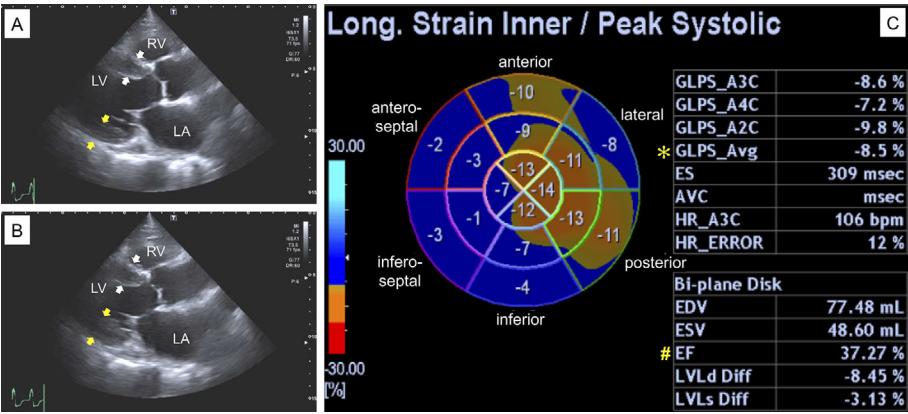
Echocardiogram findings recorded on admission (Case 2). A normal-sized left ventricle with an end-diastolic dimension of 48.1 mm and an increase in the interventricular septum thickness (white arrows) and left ventricular (LV) posterior wall thickness (yellow arrows) of 13.7 and 12.3 mm, respectively, and a dilated left atrium with a volume of 62.6 mL/m² are shown (A, end-diastole; B, end-systole). The bull's-eye map (C), as shown in Fig. 2, showed a reduced LV ejection fraction (EF) of 37.3% (marked with a hash mark) and an LV global longitudinal peak systolic strain (GLS) value of -8.5% (marked with an asterisk) with an LVEF/[GLS] of 4.4, indicating apical sparing (cutoff, >4.1) (C). LA: left atrium, LV: left ventricle, RV: right ventricle
